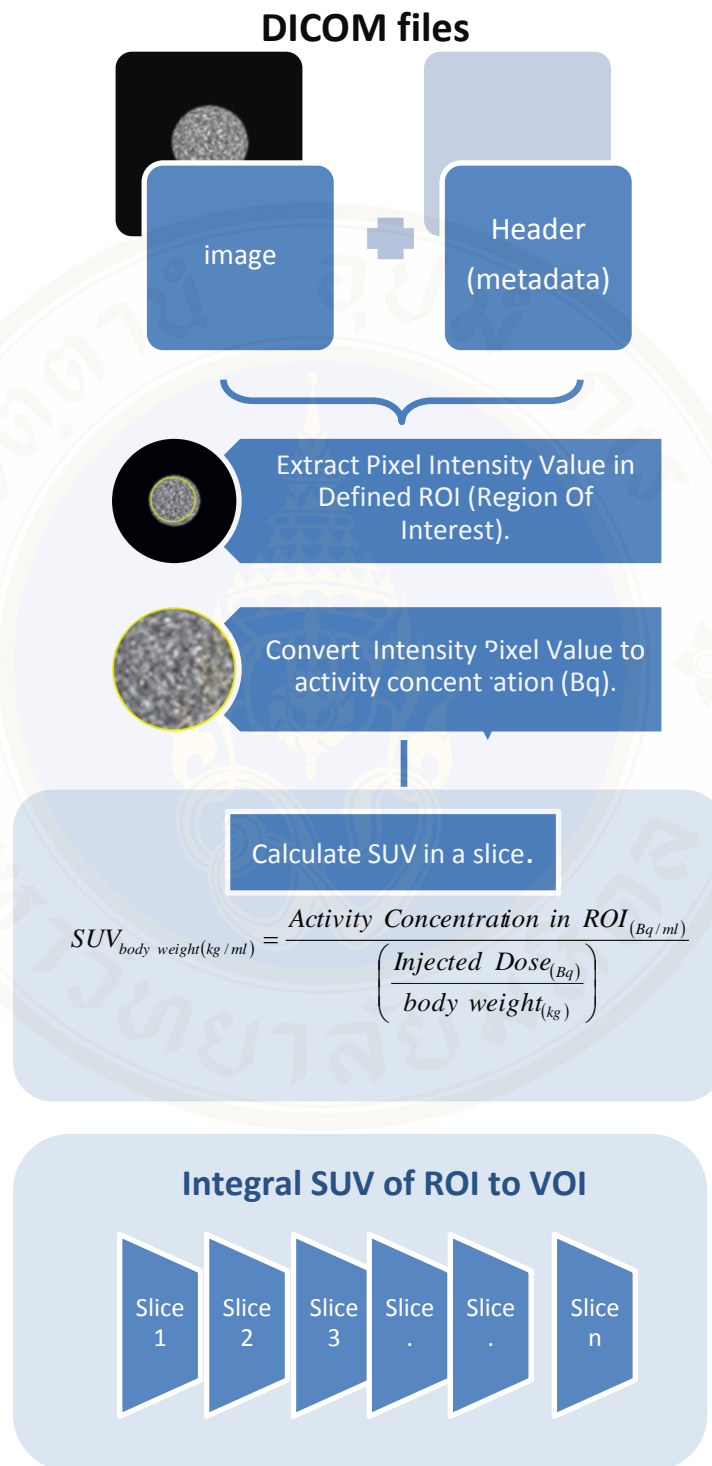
calculation of SUV in our new scheme term
